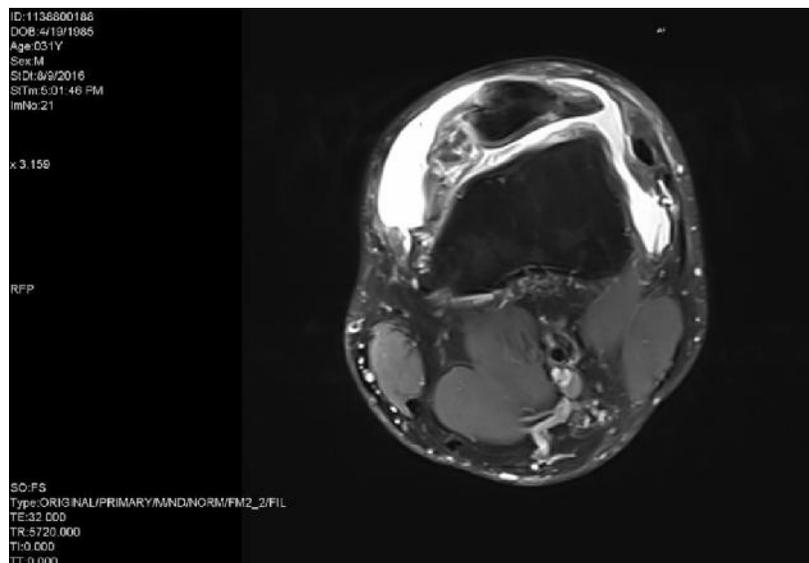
MRI axial cut shows complete tear of lateral reticulum, intact medial reticulum, vastus medialis fiber still attach to medial border of patella
